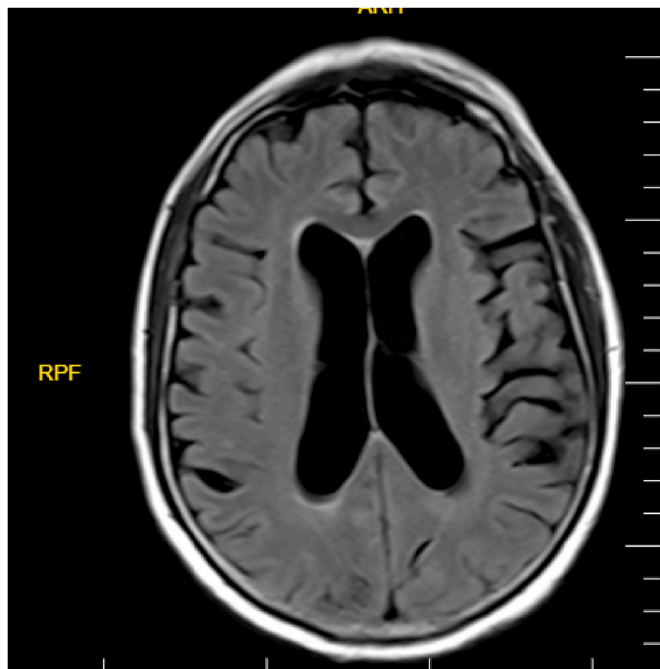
Brain MRI FLAIR sequence.
